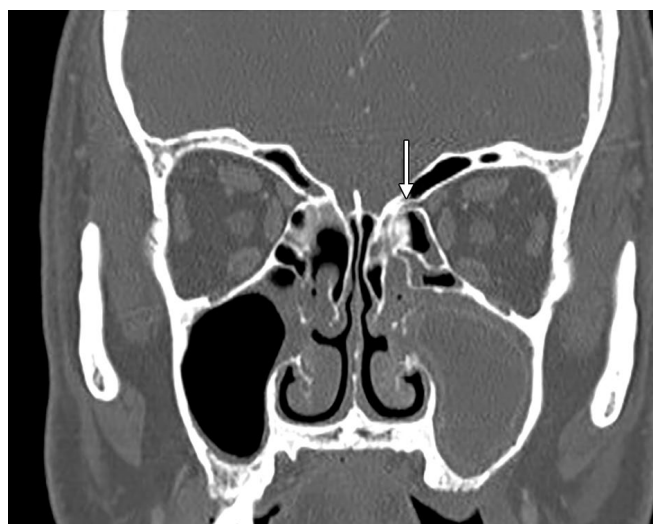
Coronal computed tomography scan demonstrating the anterior ethmoidal artery (arrow) as it exits the orbit and traverses the ethmoid cavity. Dehiscence within the ethmoid cavity places it at risk of iatrogenic injury.
